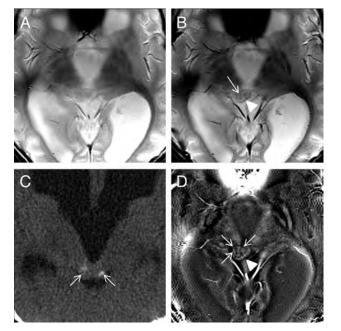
New T2* abnormality identified by 2D SWI. *A*, No T2* abnormality is seen on this baseline 2D GRE image in a 10-year-old boy with tectal glioma and associated ventriculomegaly. *B*, 2D SWI shows punctuate low-signal foci suggestive of T2* abnormality (*arrow*, *arrowhead*). *C*, This is shown as calcification/mineralization (*arrows*) by CT. *D*, 2D PU image shows a punctate low intensity (*arrows*) suggestive of calcification and foci of high intensity that may represent blood products (*arrowhead*) within the tumor.
